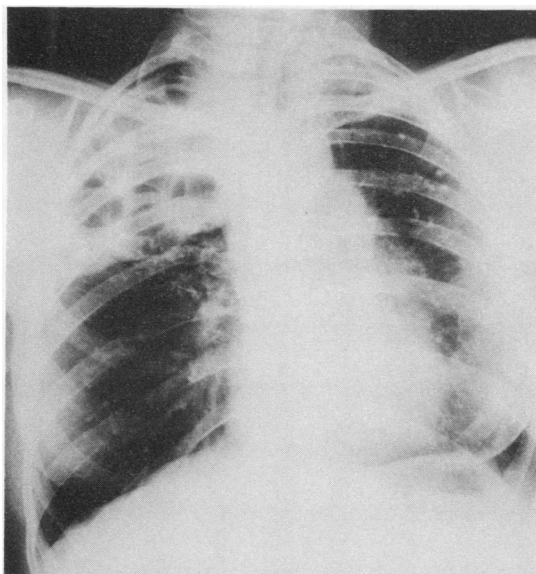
Chest radiograph demonstrating the translucent appearance of methyl methacrylate (lucite) spheres six years after insertion.
